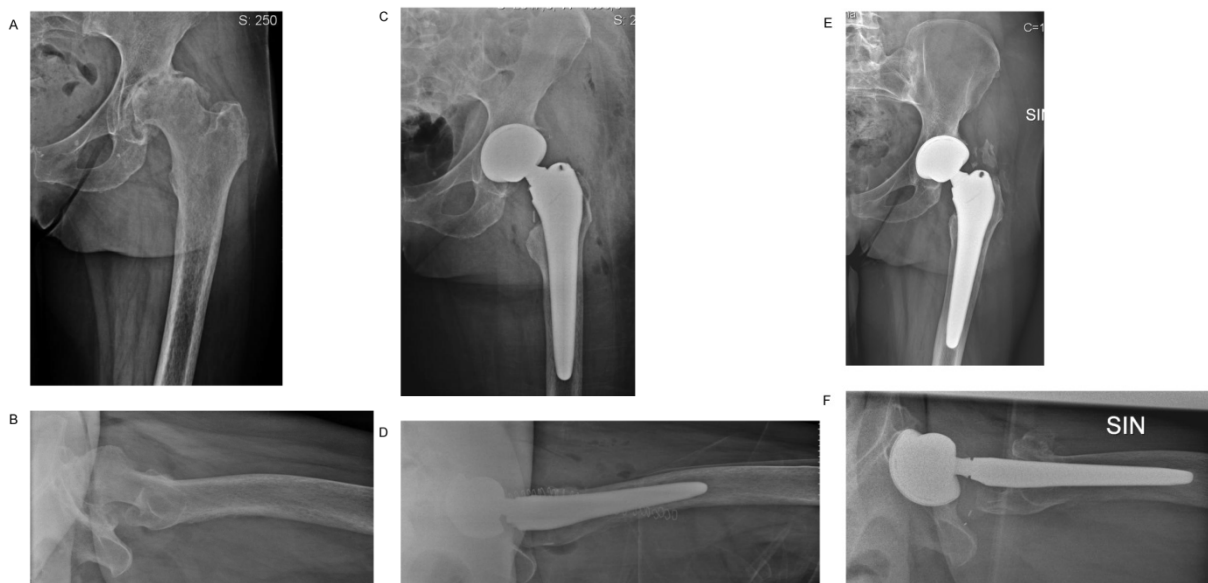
Female, 56 years old. Severe rheumatoid arthritis. Cementless total hip arthroplasty, coated with vancomycin 5% loaded DAC hydrogel. A and B. Pre-operative x-ray. Immediate (C and D) and (E and F) postoperative radiographic images at 18 months showing complete implant osteointegration at follow-up.
